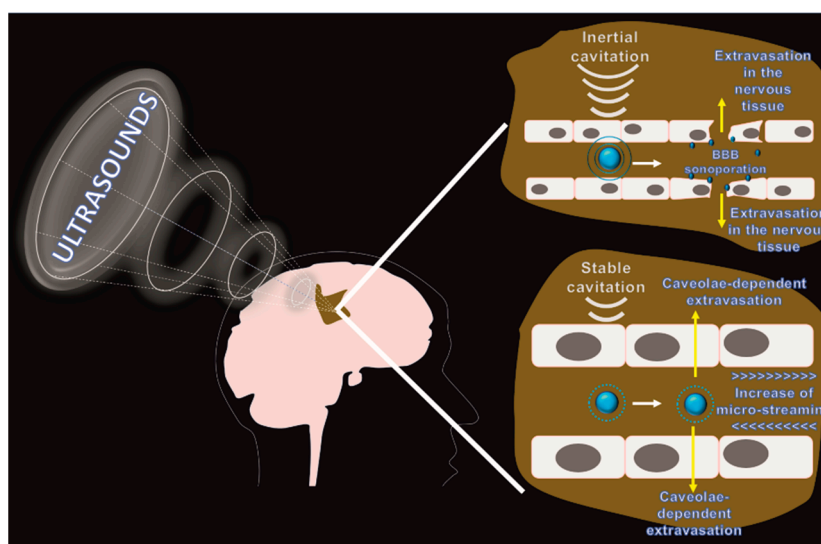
Effects of focused ultrasound on BBB permeability: External FUS is applied in combination with microbubbles injection. As a function of the acoustic pressure applied it can be obtained by: inertial cavitation and sonoporation, where relatively high levels of acoustic pressures induce the microparticles to collapse with a consequent controlled breaching of the BBB; and stable cavitation and micro-streaming where relatively low levels of acoustic pressure induce the microbubbles to vibrate increasing the flow shear stress in the proximity of the vascular wall with a consequent increase of the endothelial transport through caveolae.
